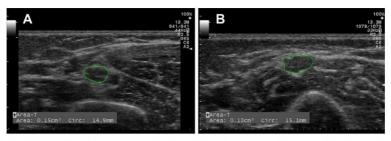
Ultrasonographic findings in a 18-year-old girl with chronic inflammatory demyelinating polyneuropathy. A. Transverse view in the middle of the upper arm showing swelling of the median nerve (our upper reference limit for cross sectional area is 0.10 cm²). Note also enlarged nerve fascicles. B. Transverse view in the middle of the upper arm showing swelling of the ulnar nerve (our upper reference limit for cross sectional area is 0.10 cm²). US of the forearm demonstrated normal nerve calibers, and continuous twitching (i.e. fasciculations) of the flexor muscles.
